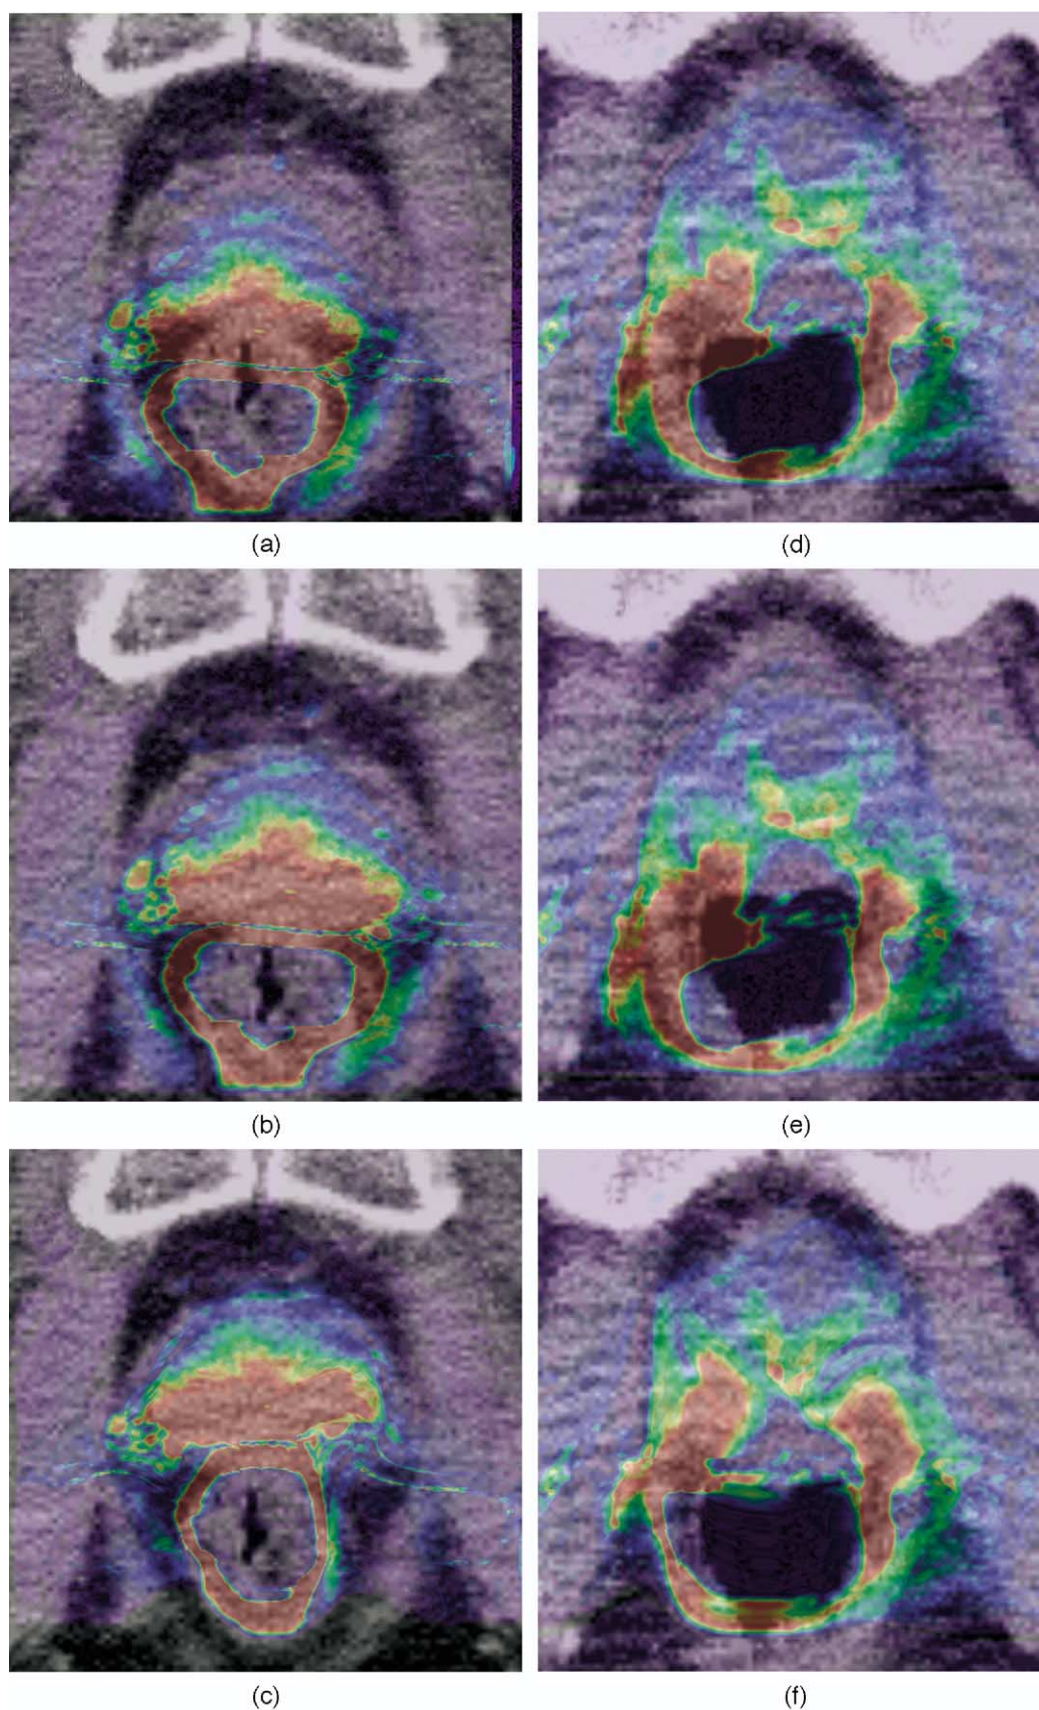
Registration result for two clinical cases. The first row shows the colored overlay of the endorectal-based magnetic resonance and computed tomography images before and after rigid and after deformable image registration for the first case. The computed tomography image is used as the background. The second row shows the same for the second clinical case.
